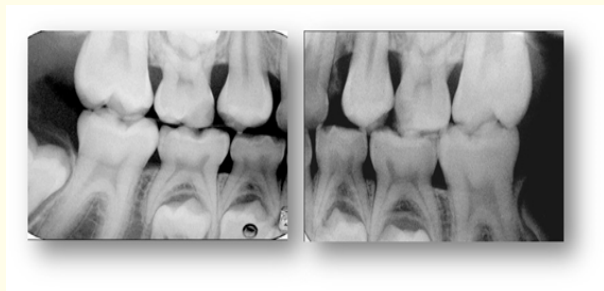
Pretreatment bitewing radiograph.
